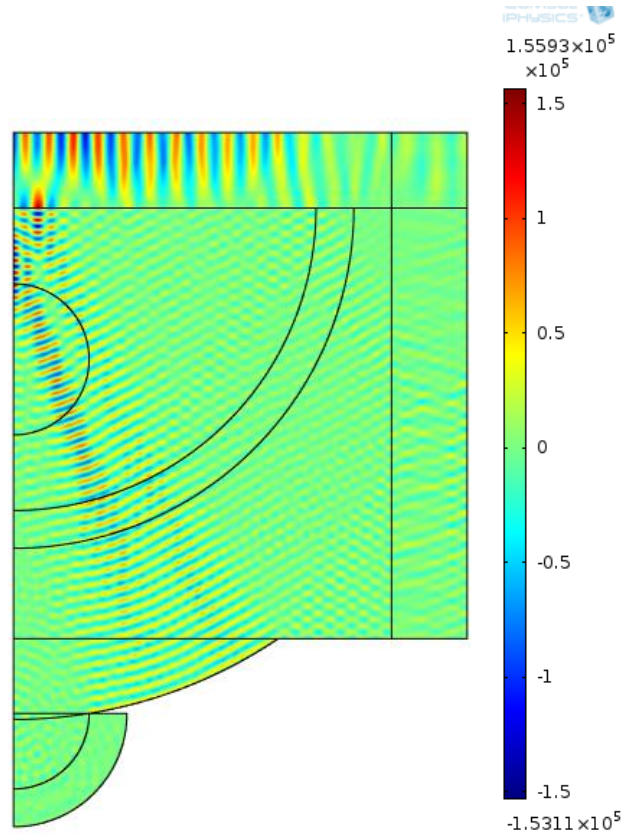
Surface plot of pressure solution, with an ultrasound frequency of 1 MHz. The focal point of the pressure field appears to be at the top of the domain, near the edge of the perfectly matched layer.
